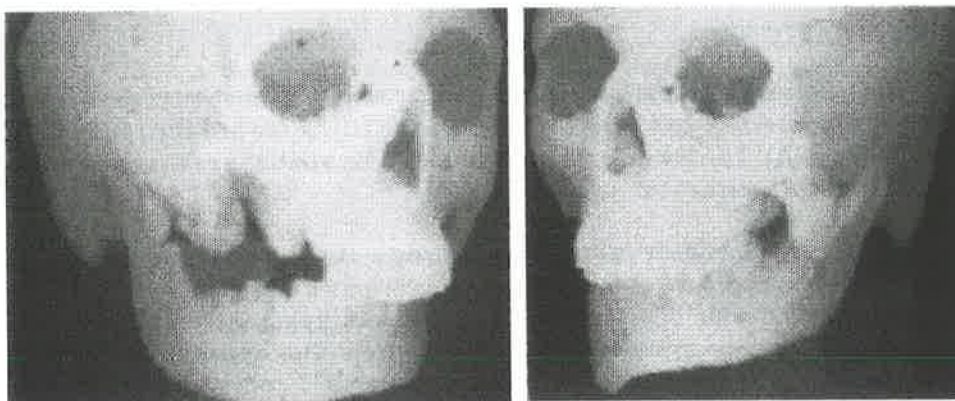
A. Eight-year-old Malaysian Chinese boy with bilateral Tessier Number 6 clefts. B. Worms-eye three-dimensional reconstruction demonstrates the skeletal hypoplasia in the region of the zygomaticomaxillary suture, which is more marked on the left side. C. Oblique three-dimensional CT reformats of the midface show the posterior maxillary and orbital hypoplasia (i-ii). D. Broad coronal two dimensional CT reformat exposes the posterior maxillary hypoplasia cleft extension into the lateral orbit. E. Coronal two-dimensional CT reformat visualises more posteriorly the mild middle cranial fossa asymmetry.
